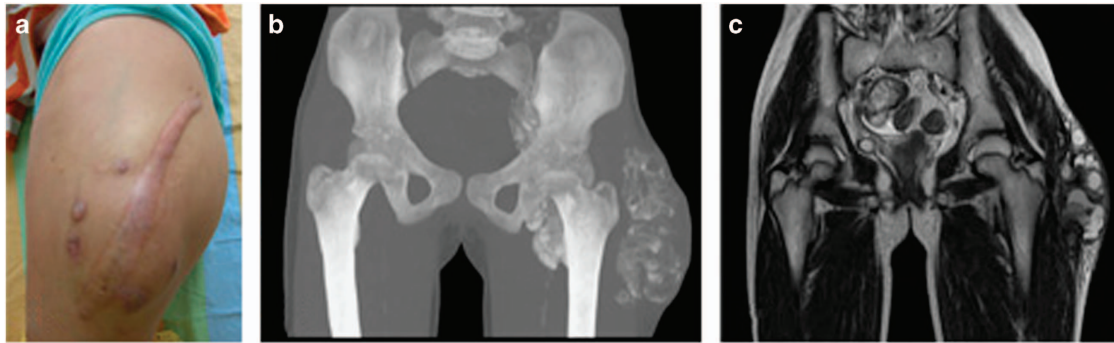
Imaging data for the sister of the patient. (a) The left hip shows a surgical scar overlying a large tumor mass. (b,c) Pelvic computed tomography (CT) with a three-dimensional reconstruction and magnetic resonance imaging (MRI) revealed a calcified left hip mass infiltrating into the pelvis.
